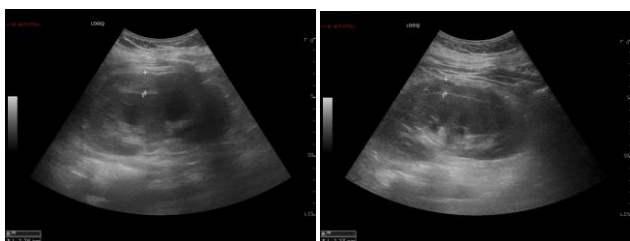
Abdomen Ultrasonography (US) documented the presence of inhomogeneous hyperechoic fluid collection in the perirenal space bilaterally, with a maximum thickness of 17 mm on the right (left figure) and 13 mm on the left (right figure).
